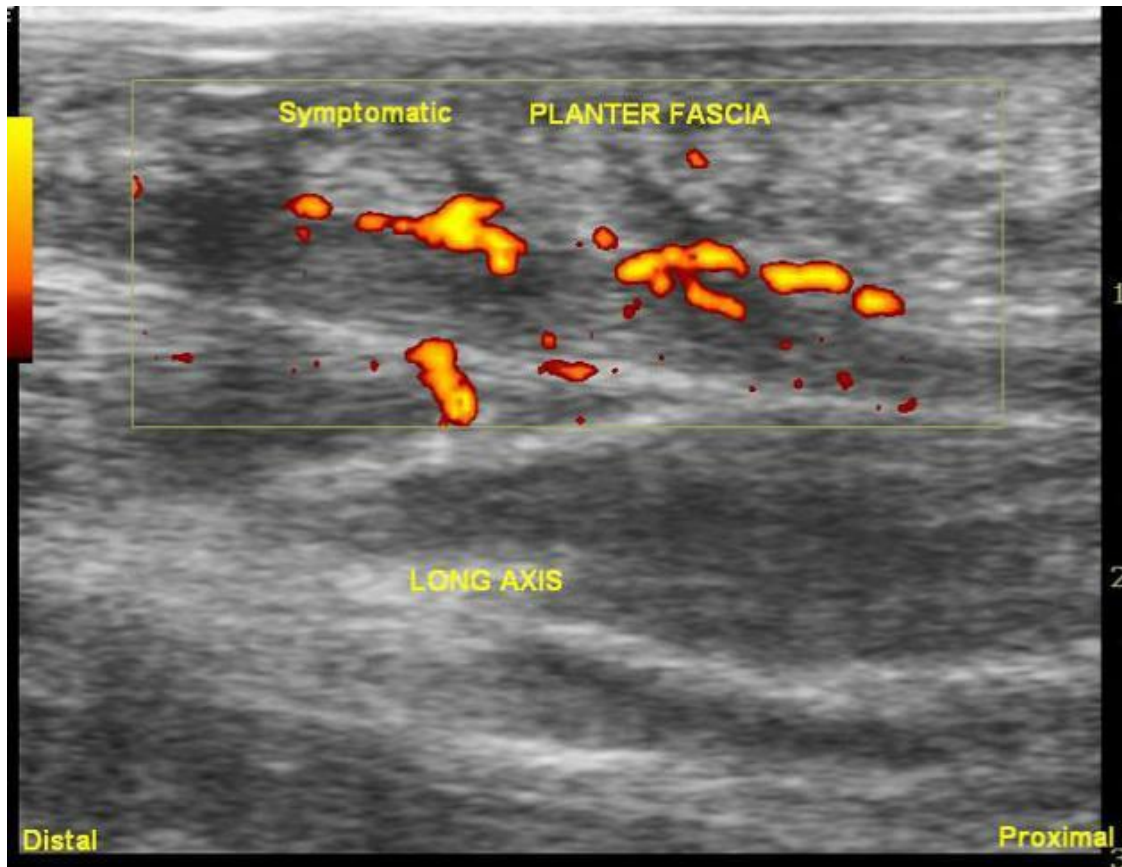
Power Doppler (box) US scan with longitudinal view of right heel shows in vascularity and hypoechoic planter fascia in patient with chronic plantar fasciitis.
